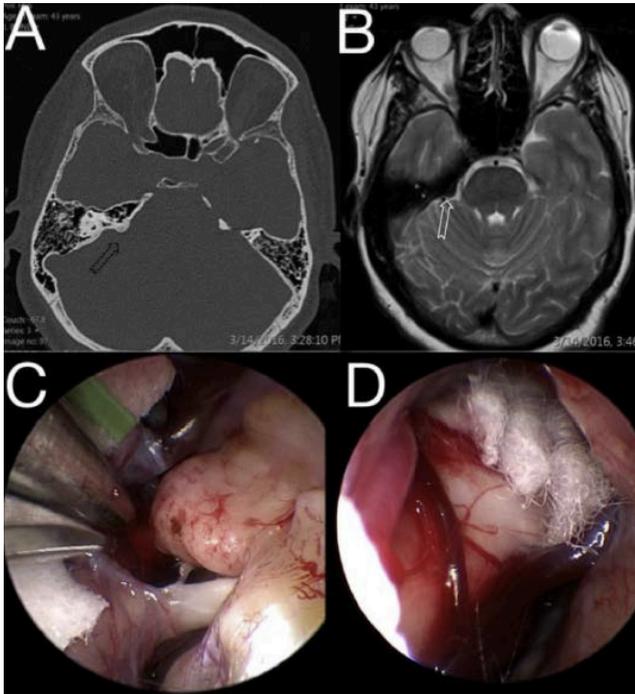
A: CT scan where a black arrow shows the right anterior SMT type III. B: A preoperative MRI shows with an arrow the enlarged SMT. C and D: Endoscopic view of the operative findings before and after drilling of the SMT.
